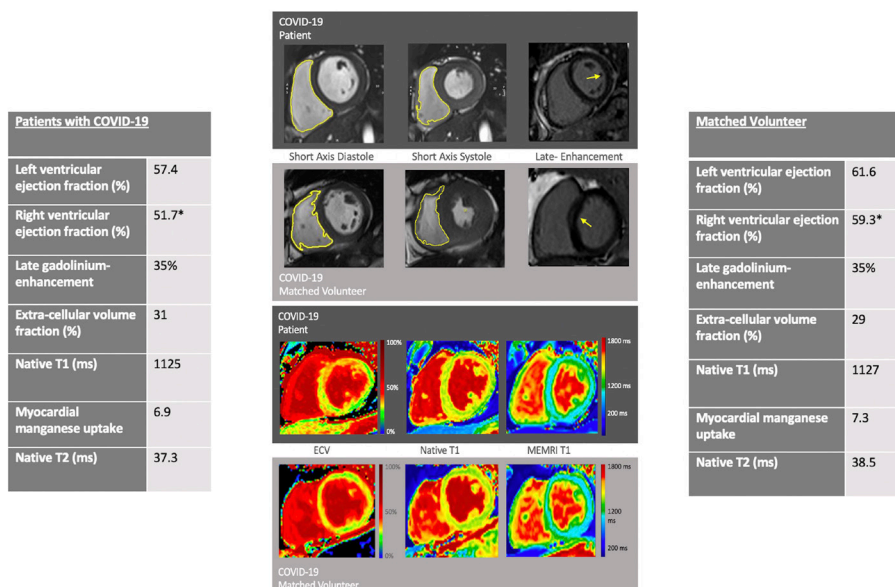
Cardiac magnetic resonance features in hospitalised COVID-19 survivors. MRI findings in patients recovering from COVID-19 infection compared with age, sex and comorbidity matched volunteers. *Statistically significant.
